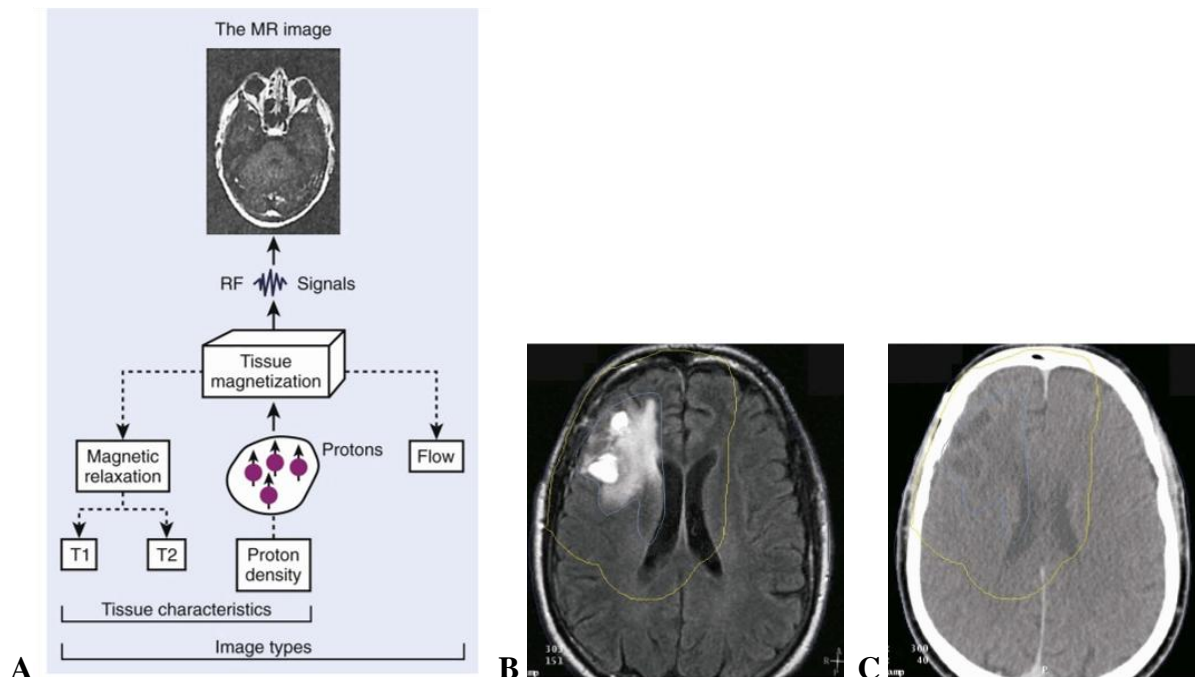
(A) Physical characteristics of tissue that are displayed in the magnetic resonance image. MR, Magnetic resonance; RF, radiofrequency; T1, spin-lattice relaxation time; T2, spin-spin relaxation time. (B) Axial T1 magnetic resonance image of the head and brain. Malignant tissue appears as brighter areas in the upper left. (C) Axial computed image of the same patient (for comparison)
